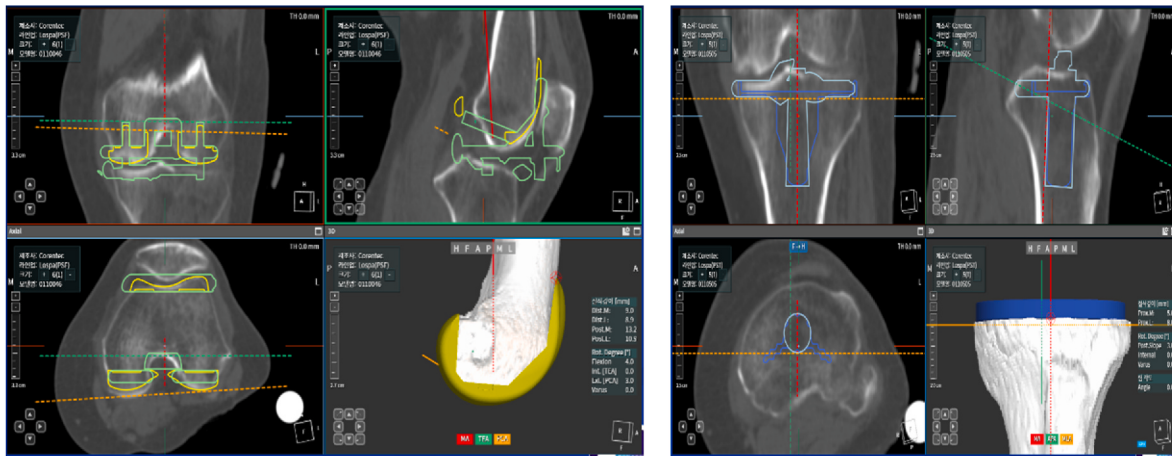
Pre-operative assessment of bone cuts and prediction of size and alignment of implants by robot software using computed tomography scan.
